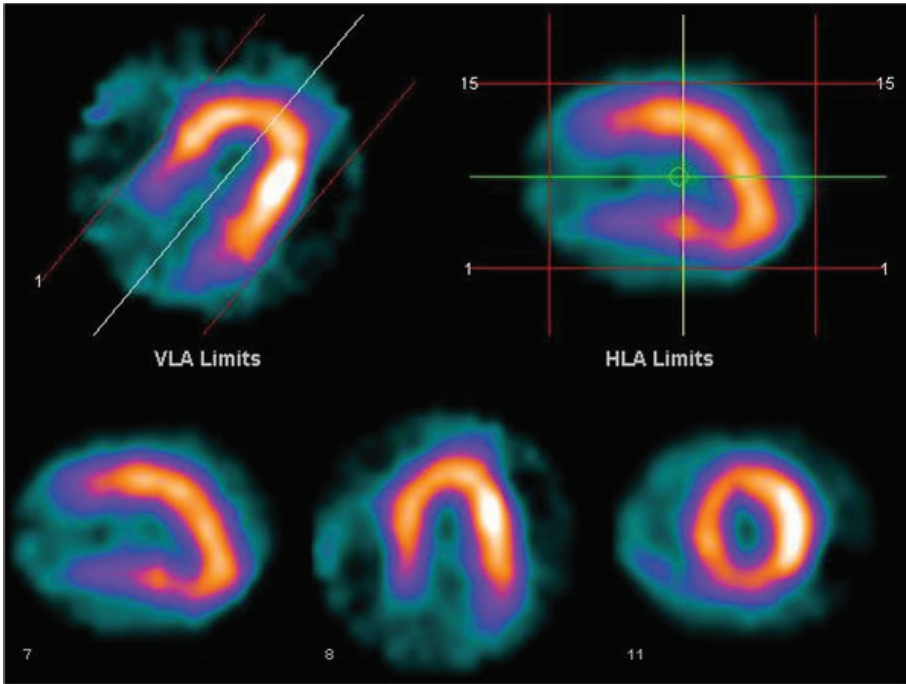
Orthogonal views of myocardial perfusion SPECT with orientation of the slices along the long axis of the heart. The upper row shows an original transaxial slice through the myocardium with the white line indicating the long axis (left) and a sagittal slice (right). The bottom row shows the reoriented views with the vertical and horizontal slices through the long axis, and a slice perpendicular to the long axis (from left to right). (Courtesy of B. König, Hanuschkrankenhaus, Vienna.)
